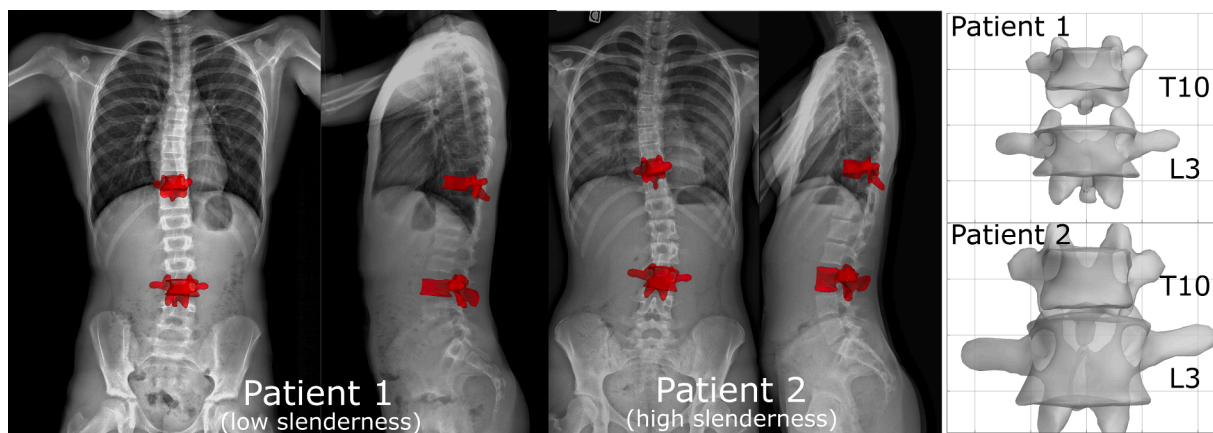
Examples of biplanar radiographs of two patients with low (Patient 1, 11 years old boy) and high slenderness ratio (Patient 2, 14 years old girl). Zooms on the 3D models of T10 and L3 vertebrae of both patients are shown; vertebrae are represented in the same scale (background grid size is 20 mm). Patient #2 has significantly taller vertebrae than patient #1, and they are only slightly larger; hence, vertebrae of patient #2 have higher slender ratio.
